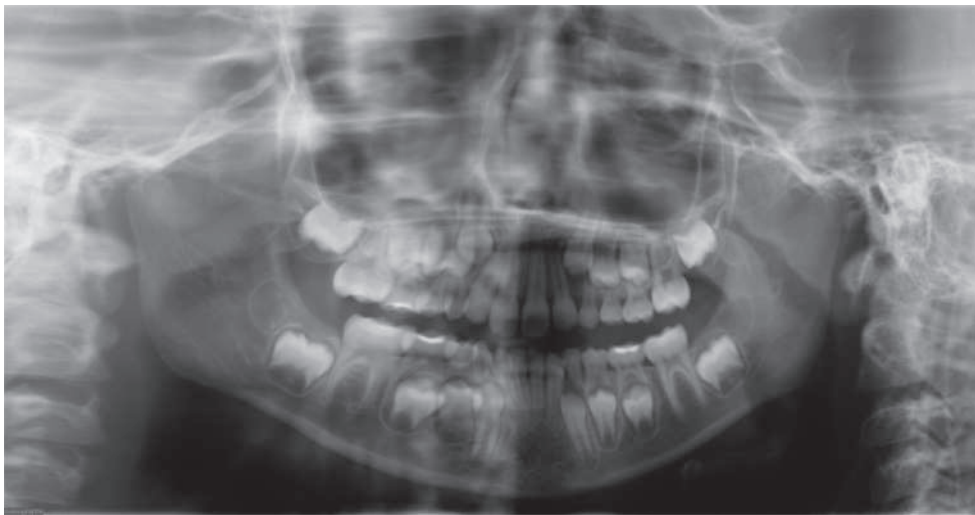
Panoramic radiograph of mixed dentition.
